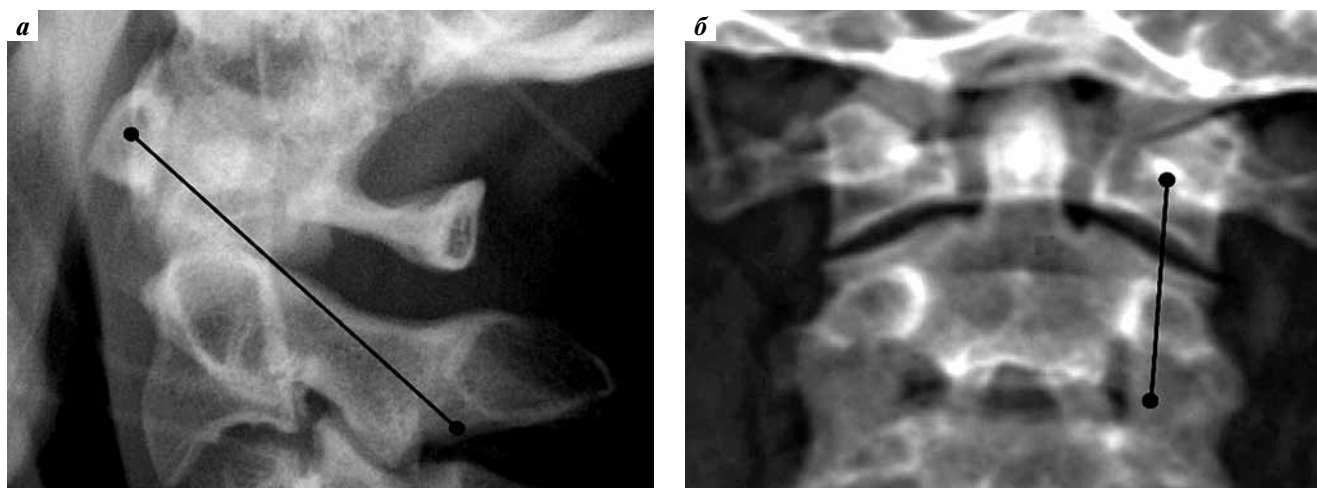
Roentgenograms in lateral (a) and straight (б) projections demonstrating the safest trajectory of transarticular fixation
